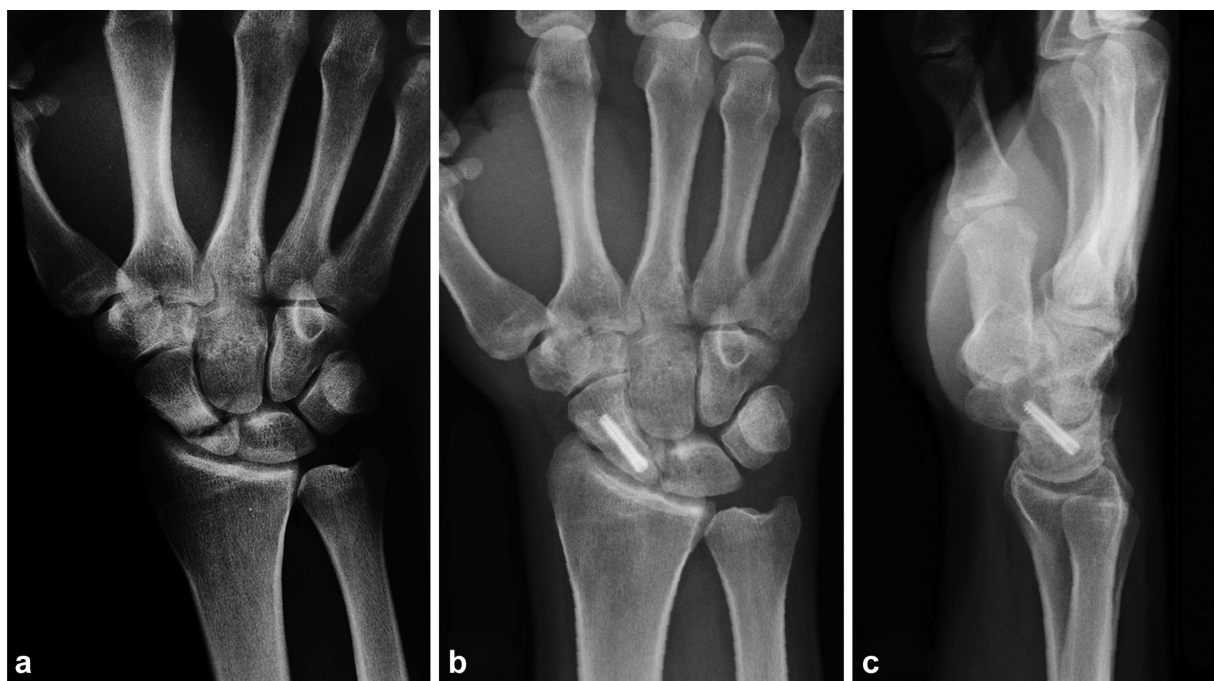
Pre- and postoperative radiographs of a scaphoid nonunion with avascular necrosis. (a) Preoperative posteroanterior radiograph of a proximal pole scaphoid nonunion with avascular necrosis. Postoperative (b) posteroanterior and (c) lateral radiographs of a healed scaphoid nonunion with avascular necrosis fixed with nonvascularized bone graft and screw fixation.
